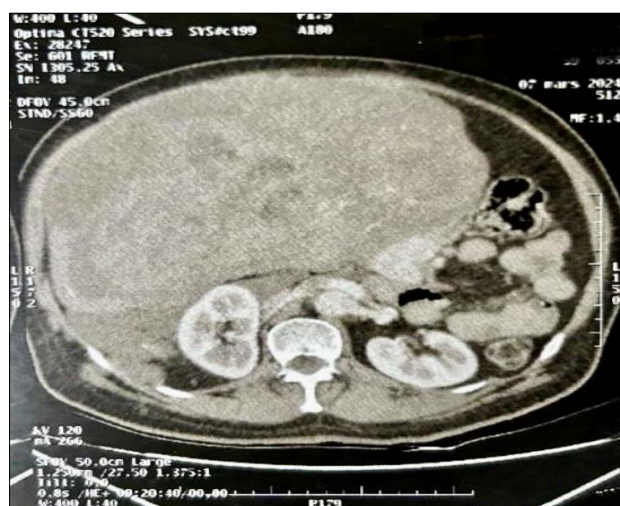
CT scan showing a right renal cortical mass with associated intraperitoneal tumor involvement.
